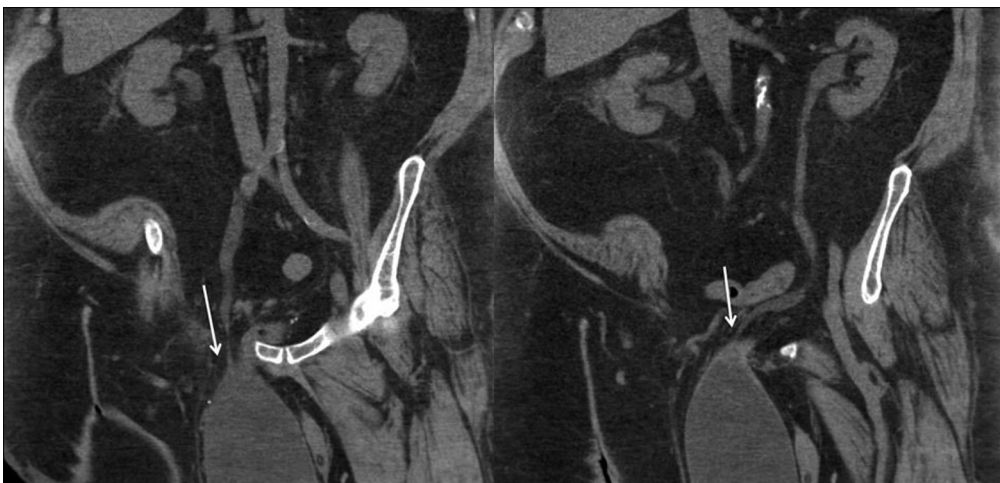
CT scan at time of presentation. Both ureters now with hydronephrosis and inserting into the bladder anterior to the pubic symphysis (arrows).
